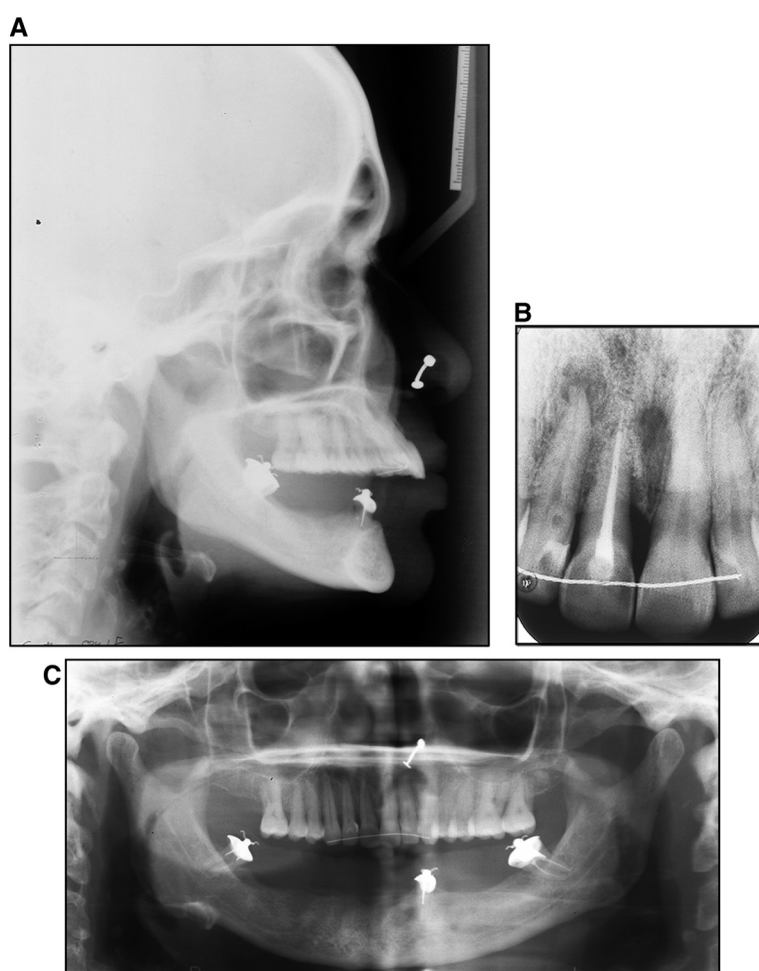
Posttreatment radiographs: A, lateral cephalogram (with the tooth-supported overdenture in place); B, panoramic radiograph; C, periapical radiograph of the maxillary right central incisor.
